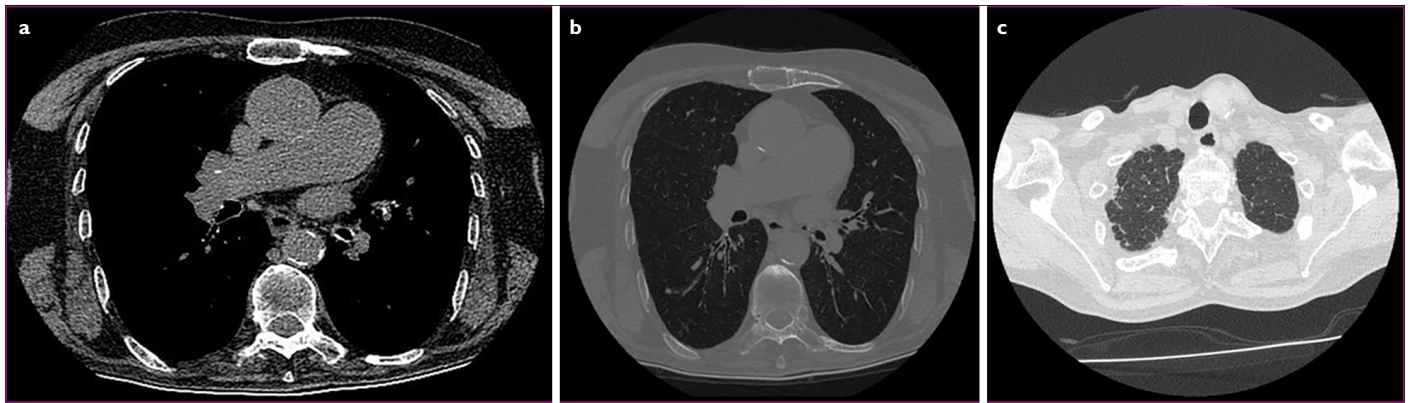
HRCT images of a patient with pulmonary hypertension: (a) Note the widening in diameter of the pulmonary artery. (b) Interlobular, septal, and intralobular thickening, subpleural bundling, and (c) Interlobular, septal and intralobular thickening, micronodules are observed.
